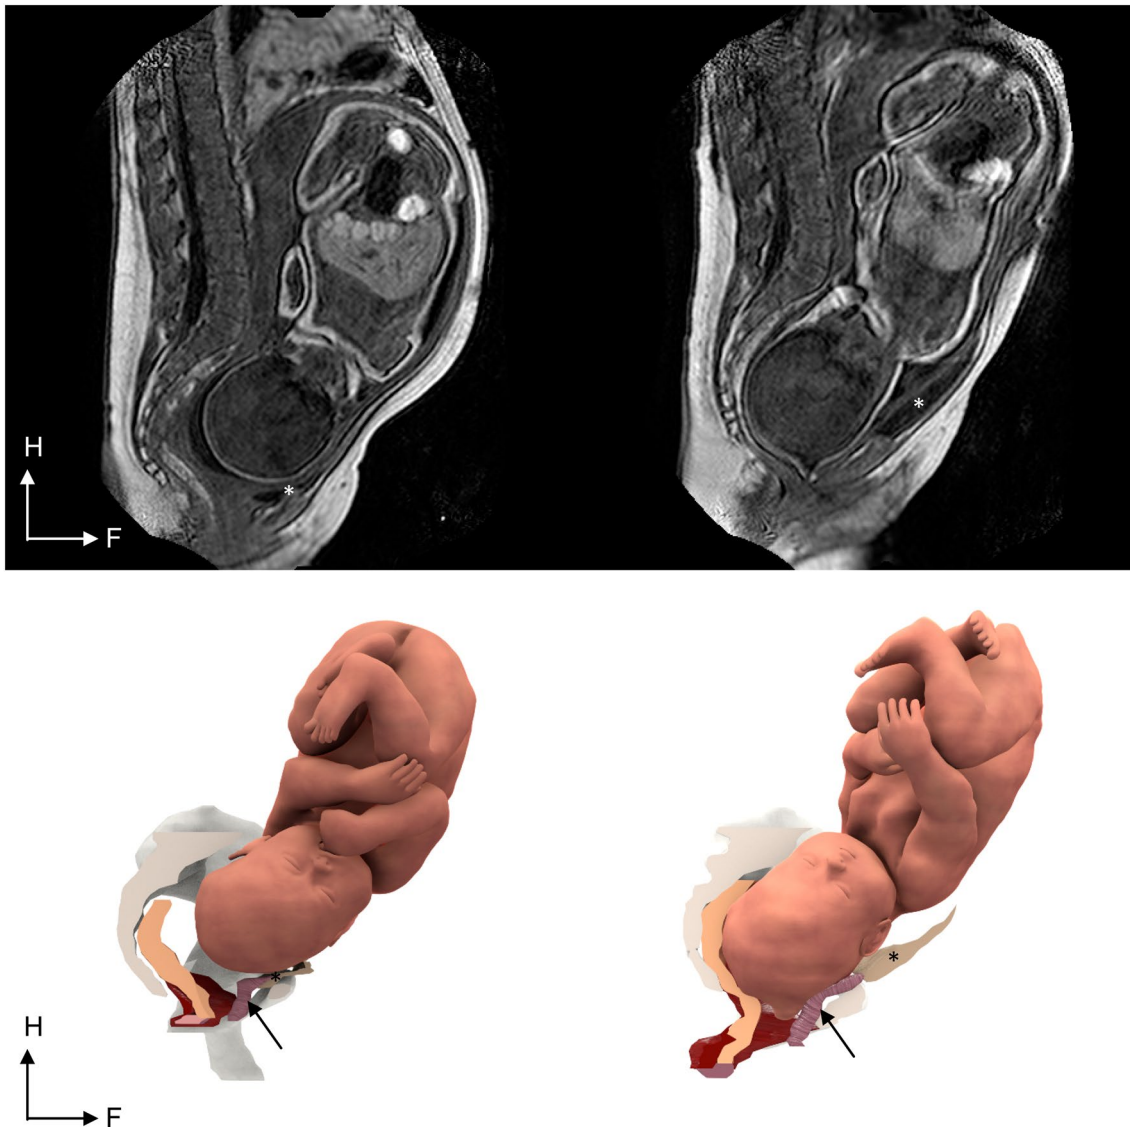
Imaging of the bladder before (left) and during (right) the second phase of labor, in MRI slices (up) and 3D (down). Before labor, the bladder is located between the fetal head and the pubis. The fetal
